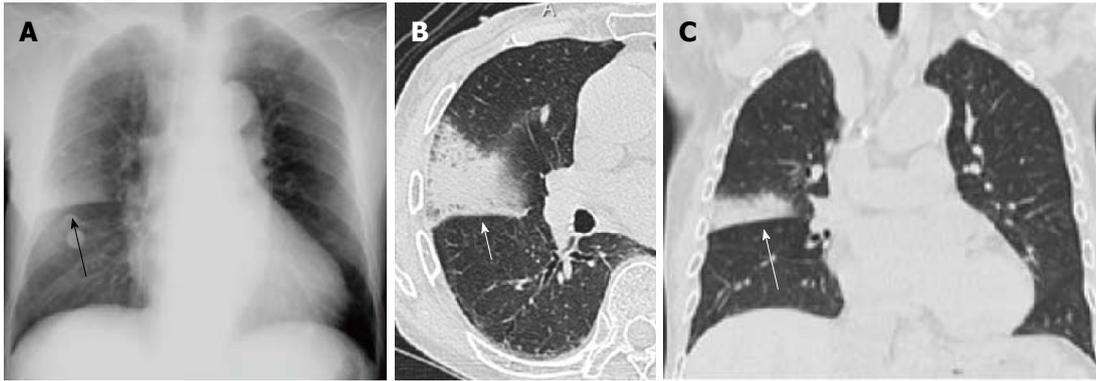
Streptococcus pneumoniae* pneumonia showing alveolar pneumonia in a man in his 80s. A: Chest radiograph shows a nonsegmental consolidation in the right middle lung field, which is demarcated by the minor fissure suggestive of upper lobe pneumonia (arrow); B, C: Thin-section computed tomography (B) and a coronal reformatted image (C) demonstrate a nonsegmental consolidation with air bronchograms suggestive of alveolar pneumonia (arrows).
